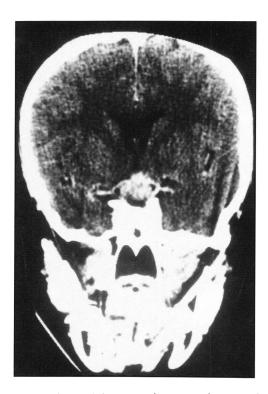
Axial computed tomography coronal views of suprasellar region (December 1989). An enhancing lobulated suprasellar mass is seen, compatible with posterior extension of malignant astrocytoma to involve hypothalamus and optic chiasm.
